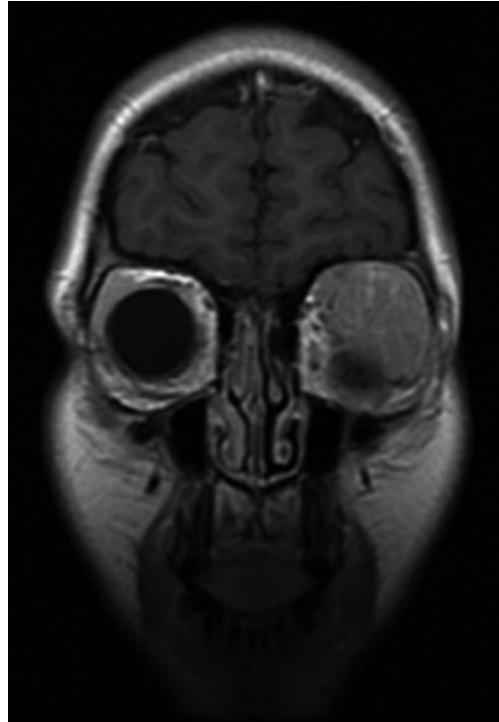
Magnetic resonance images of a 10-year-old girl with a large orbital rhabdomyosarcoma that initially presented with proptosis and periorbital swelling
